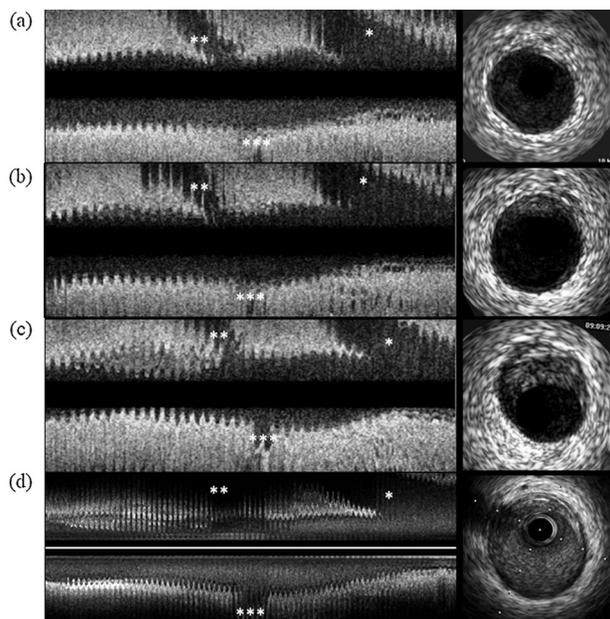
Serial changes in plaque thickness in the proximal left anterior descending coronary artery assessed by intravascular ultrasound (IVUS). Single (*), double (), and triple (*) asterisks indicate the left circumflex artery, first diagonal branch, and first septal branch, respectively. Focusing on the site between the first diagonal branch to second septal branch where plaque progression and regression took place, we measured maximum plaque thickness, minimum lumen area as well as lumen and plaque volume indices using Simpson's method. (a) No obvious plaque was detected at 3 months. (b) At 1 year, longitudinal and cross-sectional images showed that a focal eccentric plaque was observed in an area distal to first diagonal branch. (c) The plaque thickness had increased by 2 years, as shown in both the longitudinal and cross-sectional images, with decreased lumen area. (d) Although it was difficult to see the first diagonal branch due to wire artifact after transplantation, at 3 years, both the longitudinal and cross-sectional images showed decreased plaque thickness with enlarged lumen area, which was associated with everolimus administration. We note that IVUS was performed in a standard fashion using an automated and motorized 1.0 mm/s pullback with a commercially available imaging system with a 20-MHz IVUS catheter (Volcano Corp, Rancho Cordova, CA, USA) at 3 months, 1 year, and 2 years after surgery, and an automated motorized 0.5 mm/s pullback with a 40-MHz IVUS catheter (Boston Scientific Corp., Natick, MA, USA) at 3 years after surgery, respectively.
